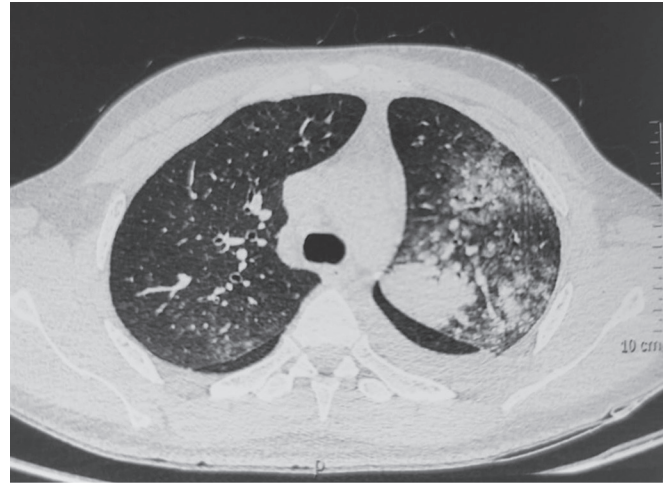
High-resolution chest CT displayed consolidation in the left lingula
